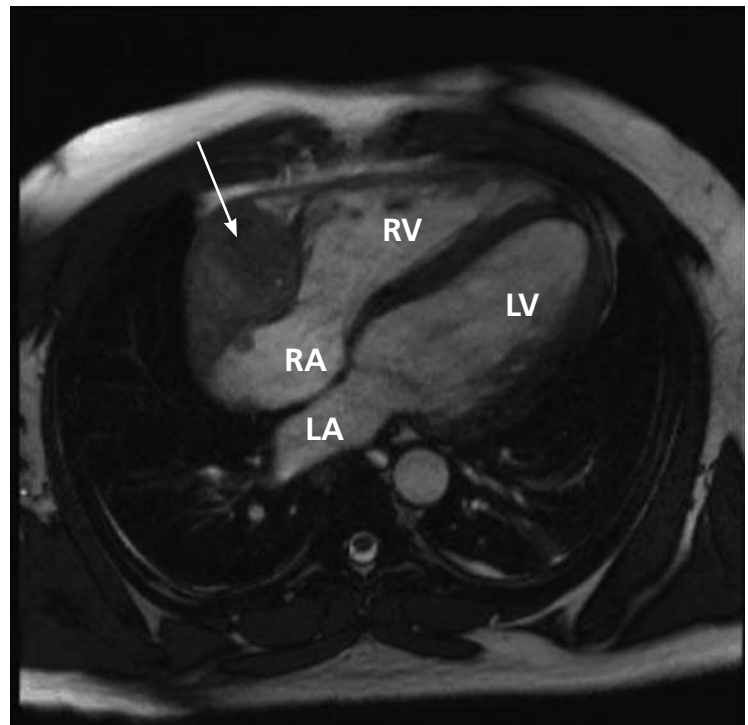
Cardiac MRI; arrow points to the tumor. RA = right atrium, RV = right ventricle, LA = left atrium, LV = left ventricle.
